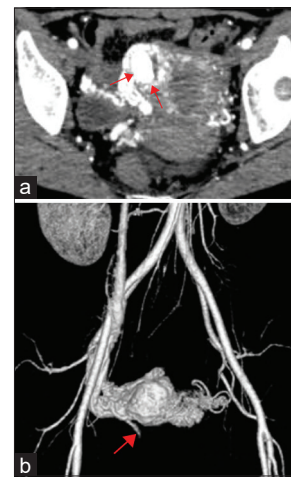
Pelvic contrast computed tomography. (a) A 30-mm contrast-enhanced mass was found in the right uterine horn. (b) A uterine pseudoaneurysm was found to be present in the main draining artery of the right uterine artery. Donation of blood from the right ovarian artery and the left uterine artery was also suspected
